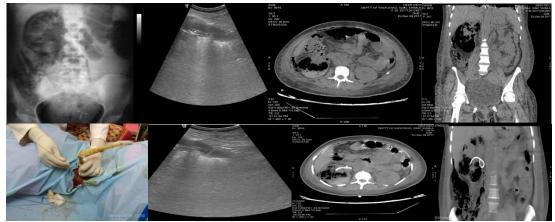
(a): abdominal radiograph shows mottled gas within renal fossa. (b) USG shows coarse echoes within renal parenchyma/ collecting system with dirty shadowing (c) axial & (d) coronal CT images show enlarged, destroyed renal parenchyma. Small bubbly or linear streaks of gas in it with gross destruction with breech in its lateral wall with resultant pneumoperitoneum. (d) percutaneous drainaige under USG guidance was done (e) USG image showing PCN tip in right kidney (f) &(g) CT images show PCN catheter in situ with decrease in air as well size of enlarged kidney.
